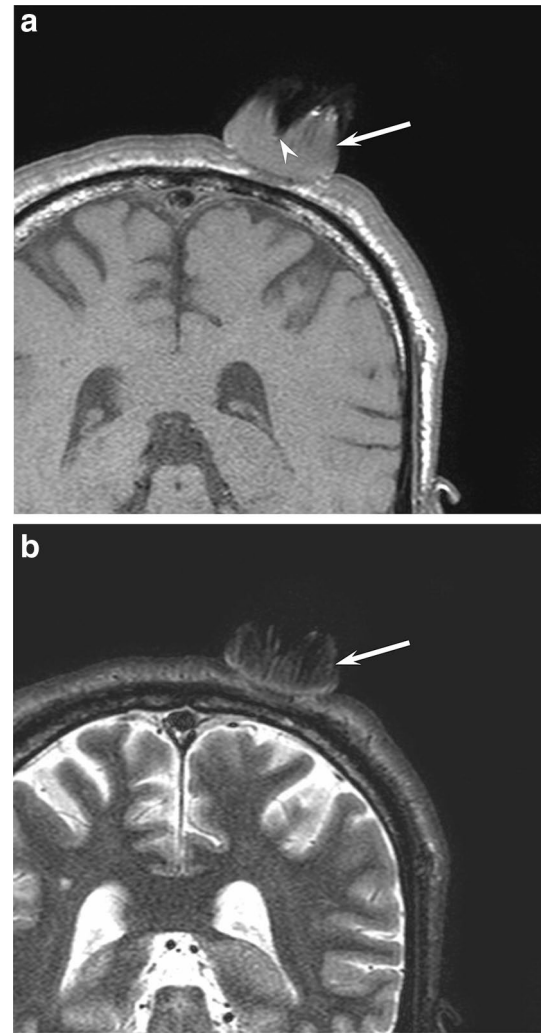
A 51-year-old man with keratoacanthoma. a T1-weighted image shows a exophytic, cup-shaped, well-demarcated cutaneous lesion (arrow) with central recesses of keratotic horn (arrow head). b Fat-suppressed T2-weighted image shows heterogeneous iso- to hypointensity (arrow)
